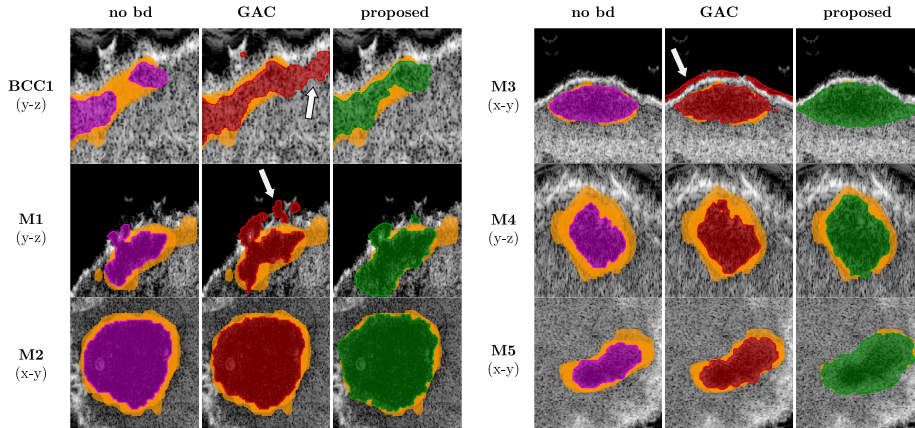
Slices of the 3D ultrasound images on one BCC (BCC1) and 5 melanoma (M1, M2, M3, M4, M5). The different columns represent the segmentation for the methods (no bd) [18] (purple), GAC [23] (red) and the proposed method (green), from left to right. The reference contours R_1 and R_2 are displayed as orange areas with half transparency (outside of the segmented contours). The orange areas are thus areas missed by the segmentation.
